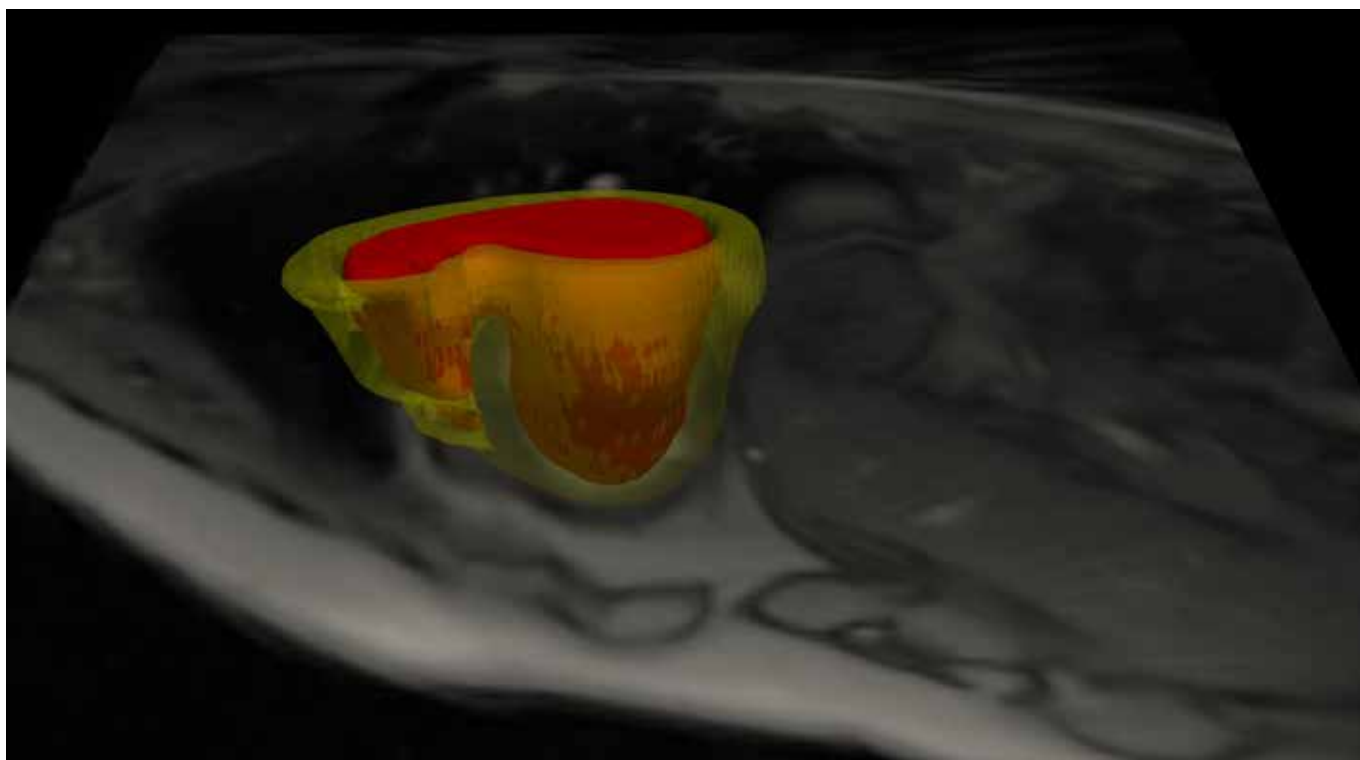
Fontan circulation with hypoplastic right heart was acquired with cardiac real-time MRI during spontaneous breathing. The cardiac short axis slices were segmented with artificial intelligence (red: blood pool and yellow: myocardial volume) sorted automatically for their cardiac and respiratory phase to create a 3D stack representing end-diastolic and end-expiratory phase. The result shows the blood pool and heart muscle. The 3D model shows the end-diastole and end expiration.
